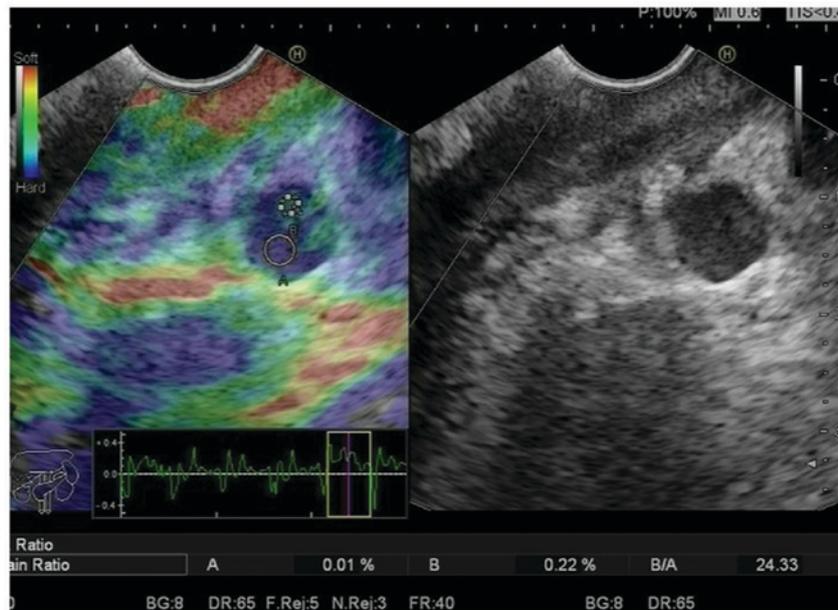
Endoscopic ultrasonography of peripheral metastatic lymph nodes.
